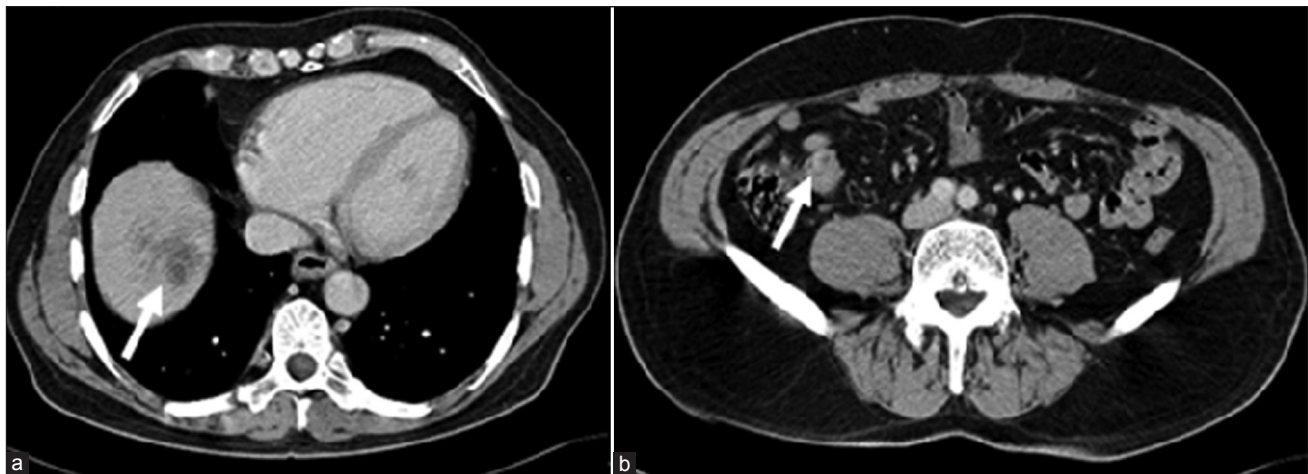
Computed Tomography demonstrating low attenuation lesion in the upper part of the liver (arrowed) consistent with metastasis (a) and also a soft tissue mass in the terminal ileum (arrowed) which represented the primary neuro-endocrine tumour (b).
